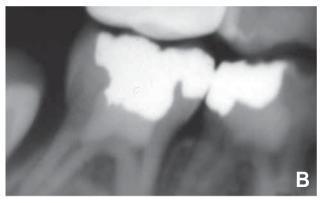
Combination of ferric sulfate and formocresol pulpotomy. (A) Tooth T prior to pulpotomy treatment with normal radiographic findings. (B) Pulpotomy treatment on tooth T at 24 months with internal resorption of mesial and distal root and possible furcation involvement. (C) Tooth T 36 months after treatment with continuing resorption and furcation involvement.
